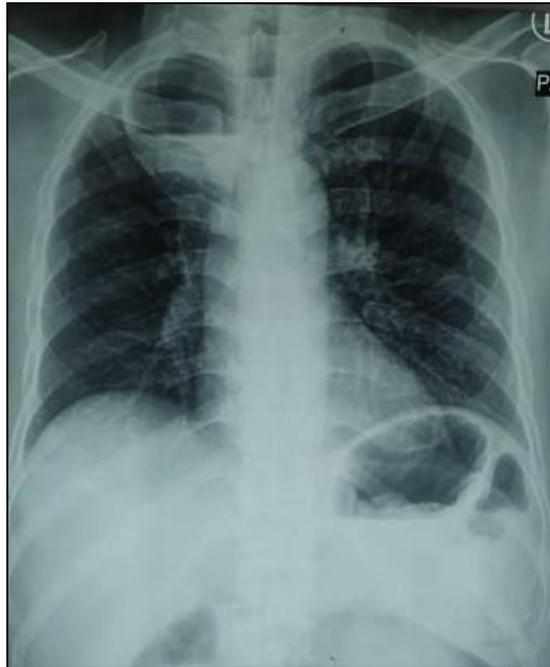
Chest radiograph shows lung opacity with air-fluid level in the right upper lobe
